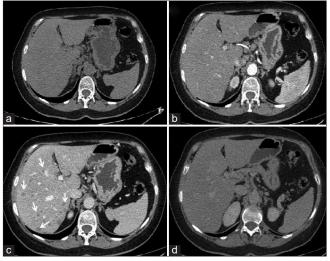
Abdominal CT. CT scans of the liver were performed before (a) and after contrast medium administration: in arterial phase (b), venous phase (c) and late phase (d), and show multiple hypodense subcentimetric lesions (arrows), with distinct margins, diffuse in all hepatic segments, detectable only in the venous phase (1 min after administration of contrast medium). CEUS: Contrast enhancement ultrasound, CT: Computed tomography
